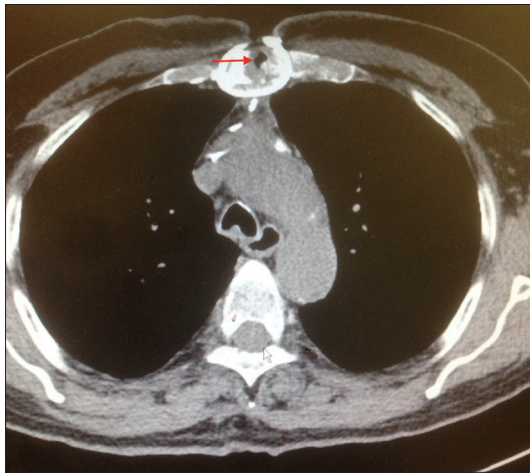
Computed tomography of the chest shows osteomyelitis of the sternum (red arrow)
